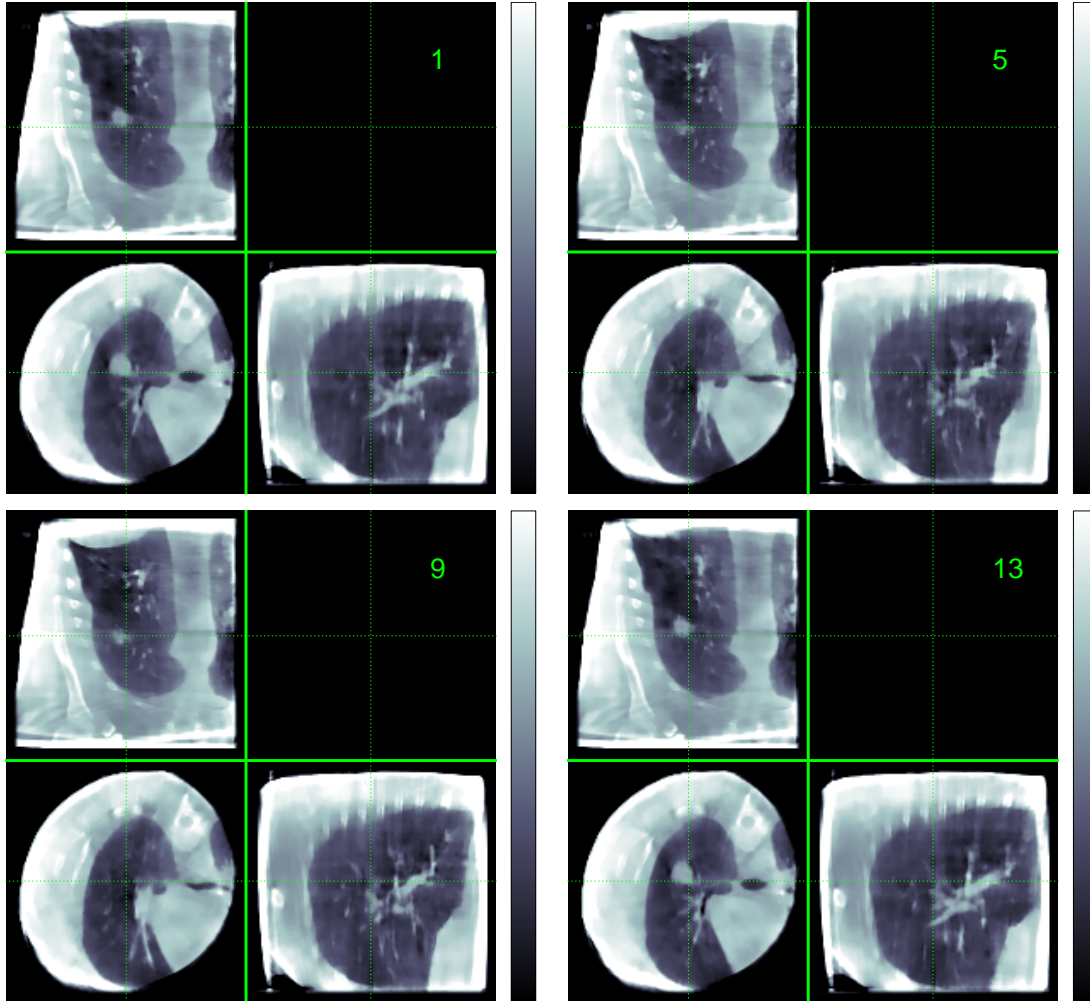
Our 3D+t reconstruction of the thorax of a patient (*Elekta Synergy Cone-Beam CT* data from [29], used by courtesy of Centre Léon Bérard). A sliced view of each frame in the axial (center), sagittal (right), and coronal (top) directions is shown.
